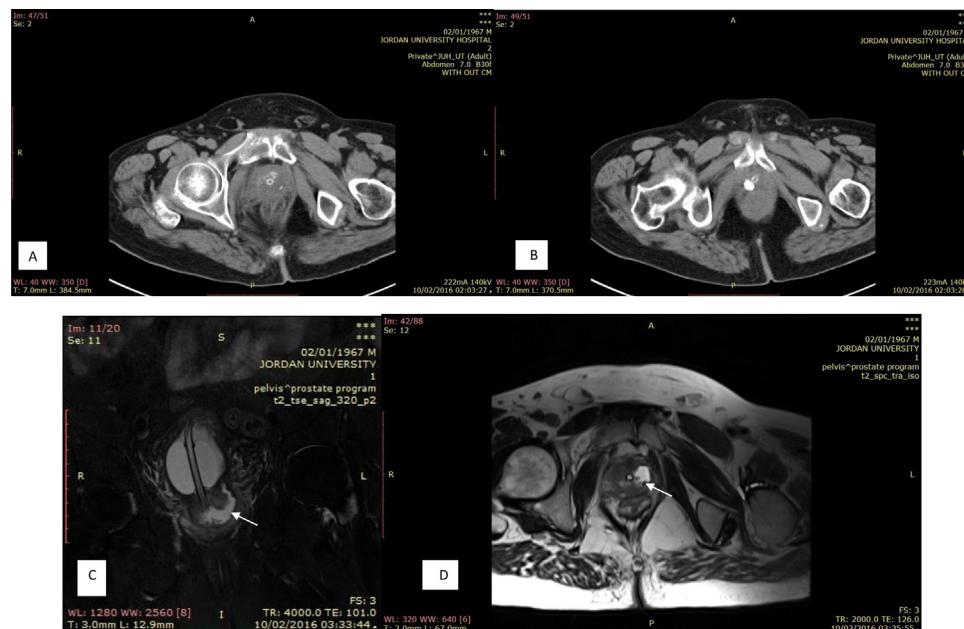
Post operation non-contrast urinary tract CT (A+B) showing only few residual stones, the largest on the right side of the prostate and pelvic MRI coronal STIR (C) showing fluid filled diverticulum in the left lateral aspect of the prostate (arrow), axial T2 (D) showing the prostatic diverticulum containing tiny hypointense stone (arrow).
